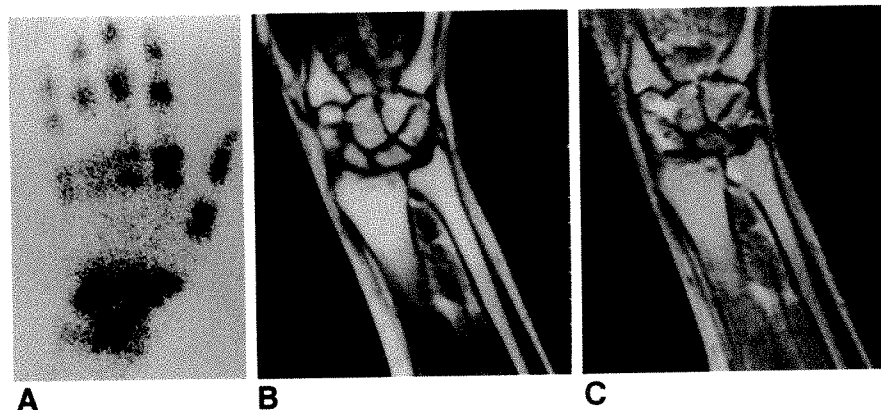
Bone scan and MR images show typical findings of reflex sympathetic dystrophy of upper extremity. A 38-year-old woman had pain in left wrist. Perfusion and blood-pool scans showed increased activity on left side.
